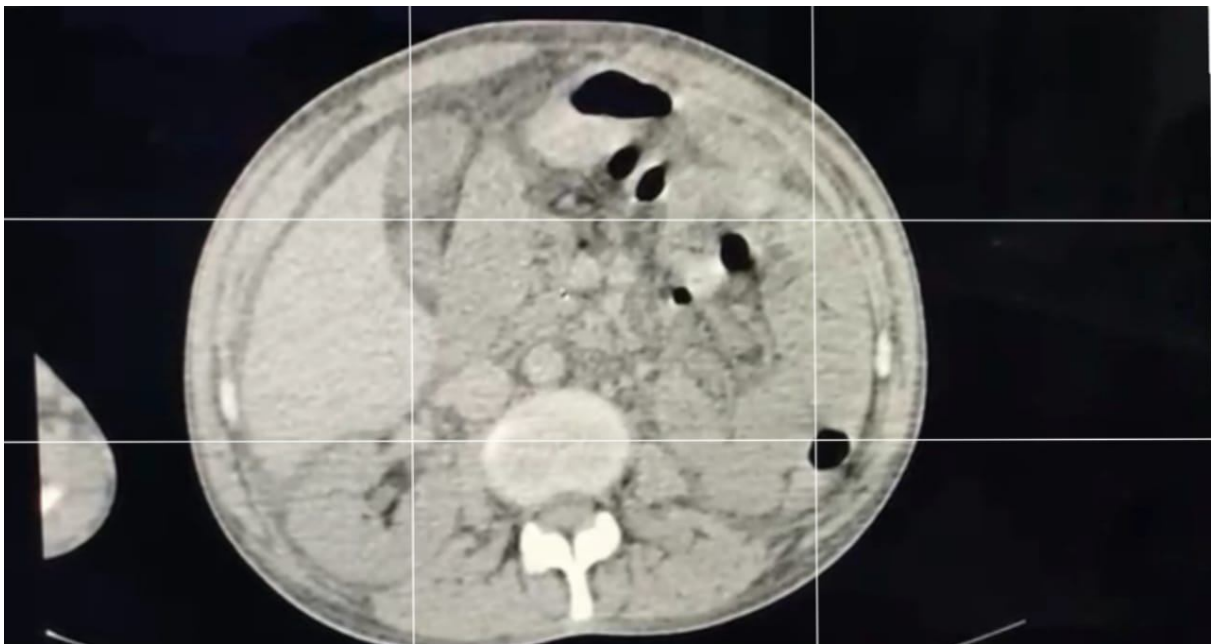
CT KUB suggestive of Right kidney in Normal shape and position while Left Kidney appearing small in size and in Left Peric cavity suggestive of Ectopic Left Kidney.
